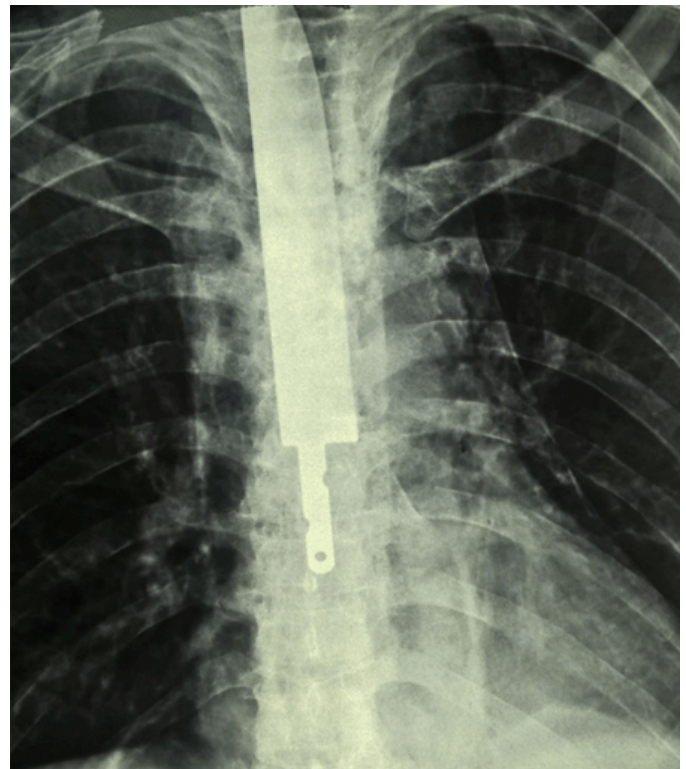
Chest X-ray examination revealing presence of knife in oesophagus.
